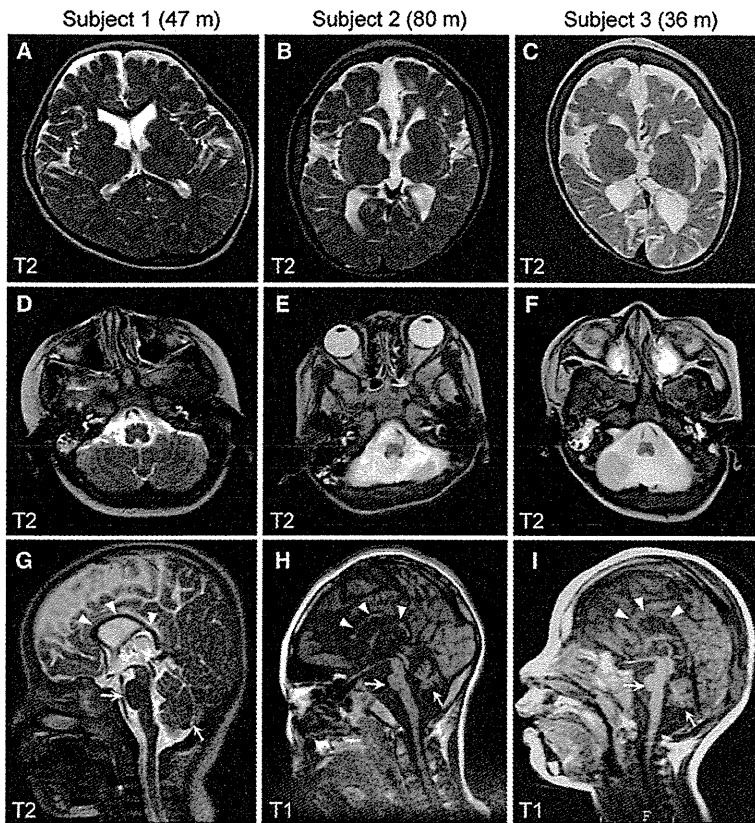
Brain MRI of Subjects with *SPTAN1* Aberrations at the Most Recent Developmental Stages
